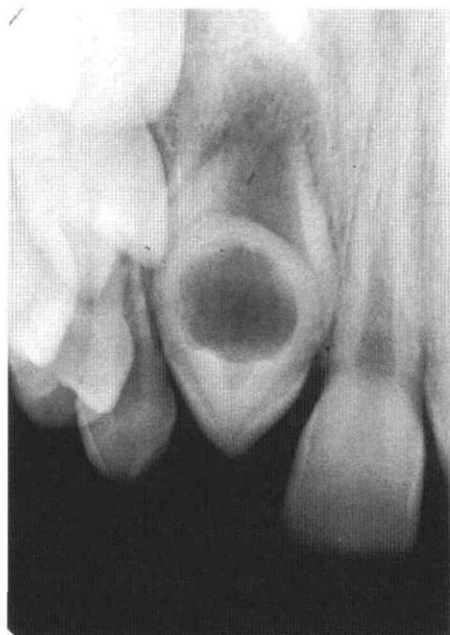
Periapical radiograph of maxillary right permanent lateral incisor (dens invaginatus).
